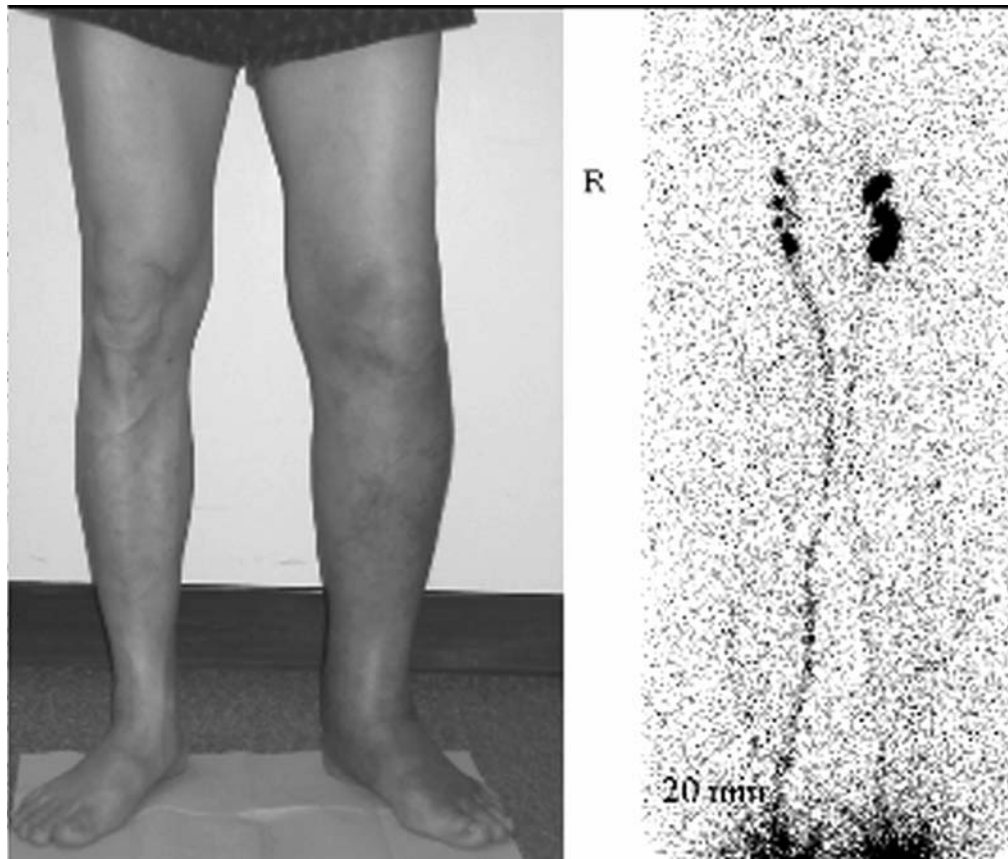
Sixty-two-year-old male with chronic swelling of left leg, previously diagnosed as primary LE. Lymphoscintigraphy (right) demonstrated intact lymphatic structures in both legs, but with accelerated lymphatic flow in affected extremity (note greater accumulation of tracer in left inguinal nodes than in right). Doppler studies subsequently confirmed venous insufficiency in left leg.
